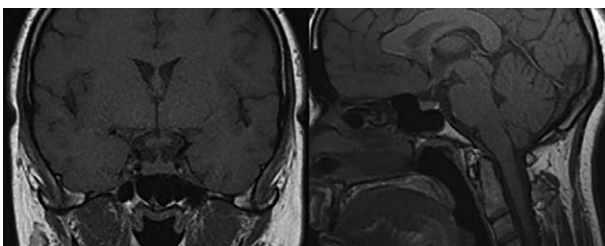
Pituitary MRI image after 3 weeks i.m LT4 treatment.
